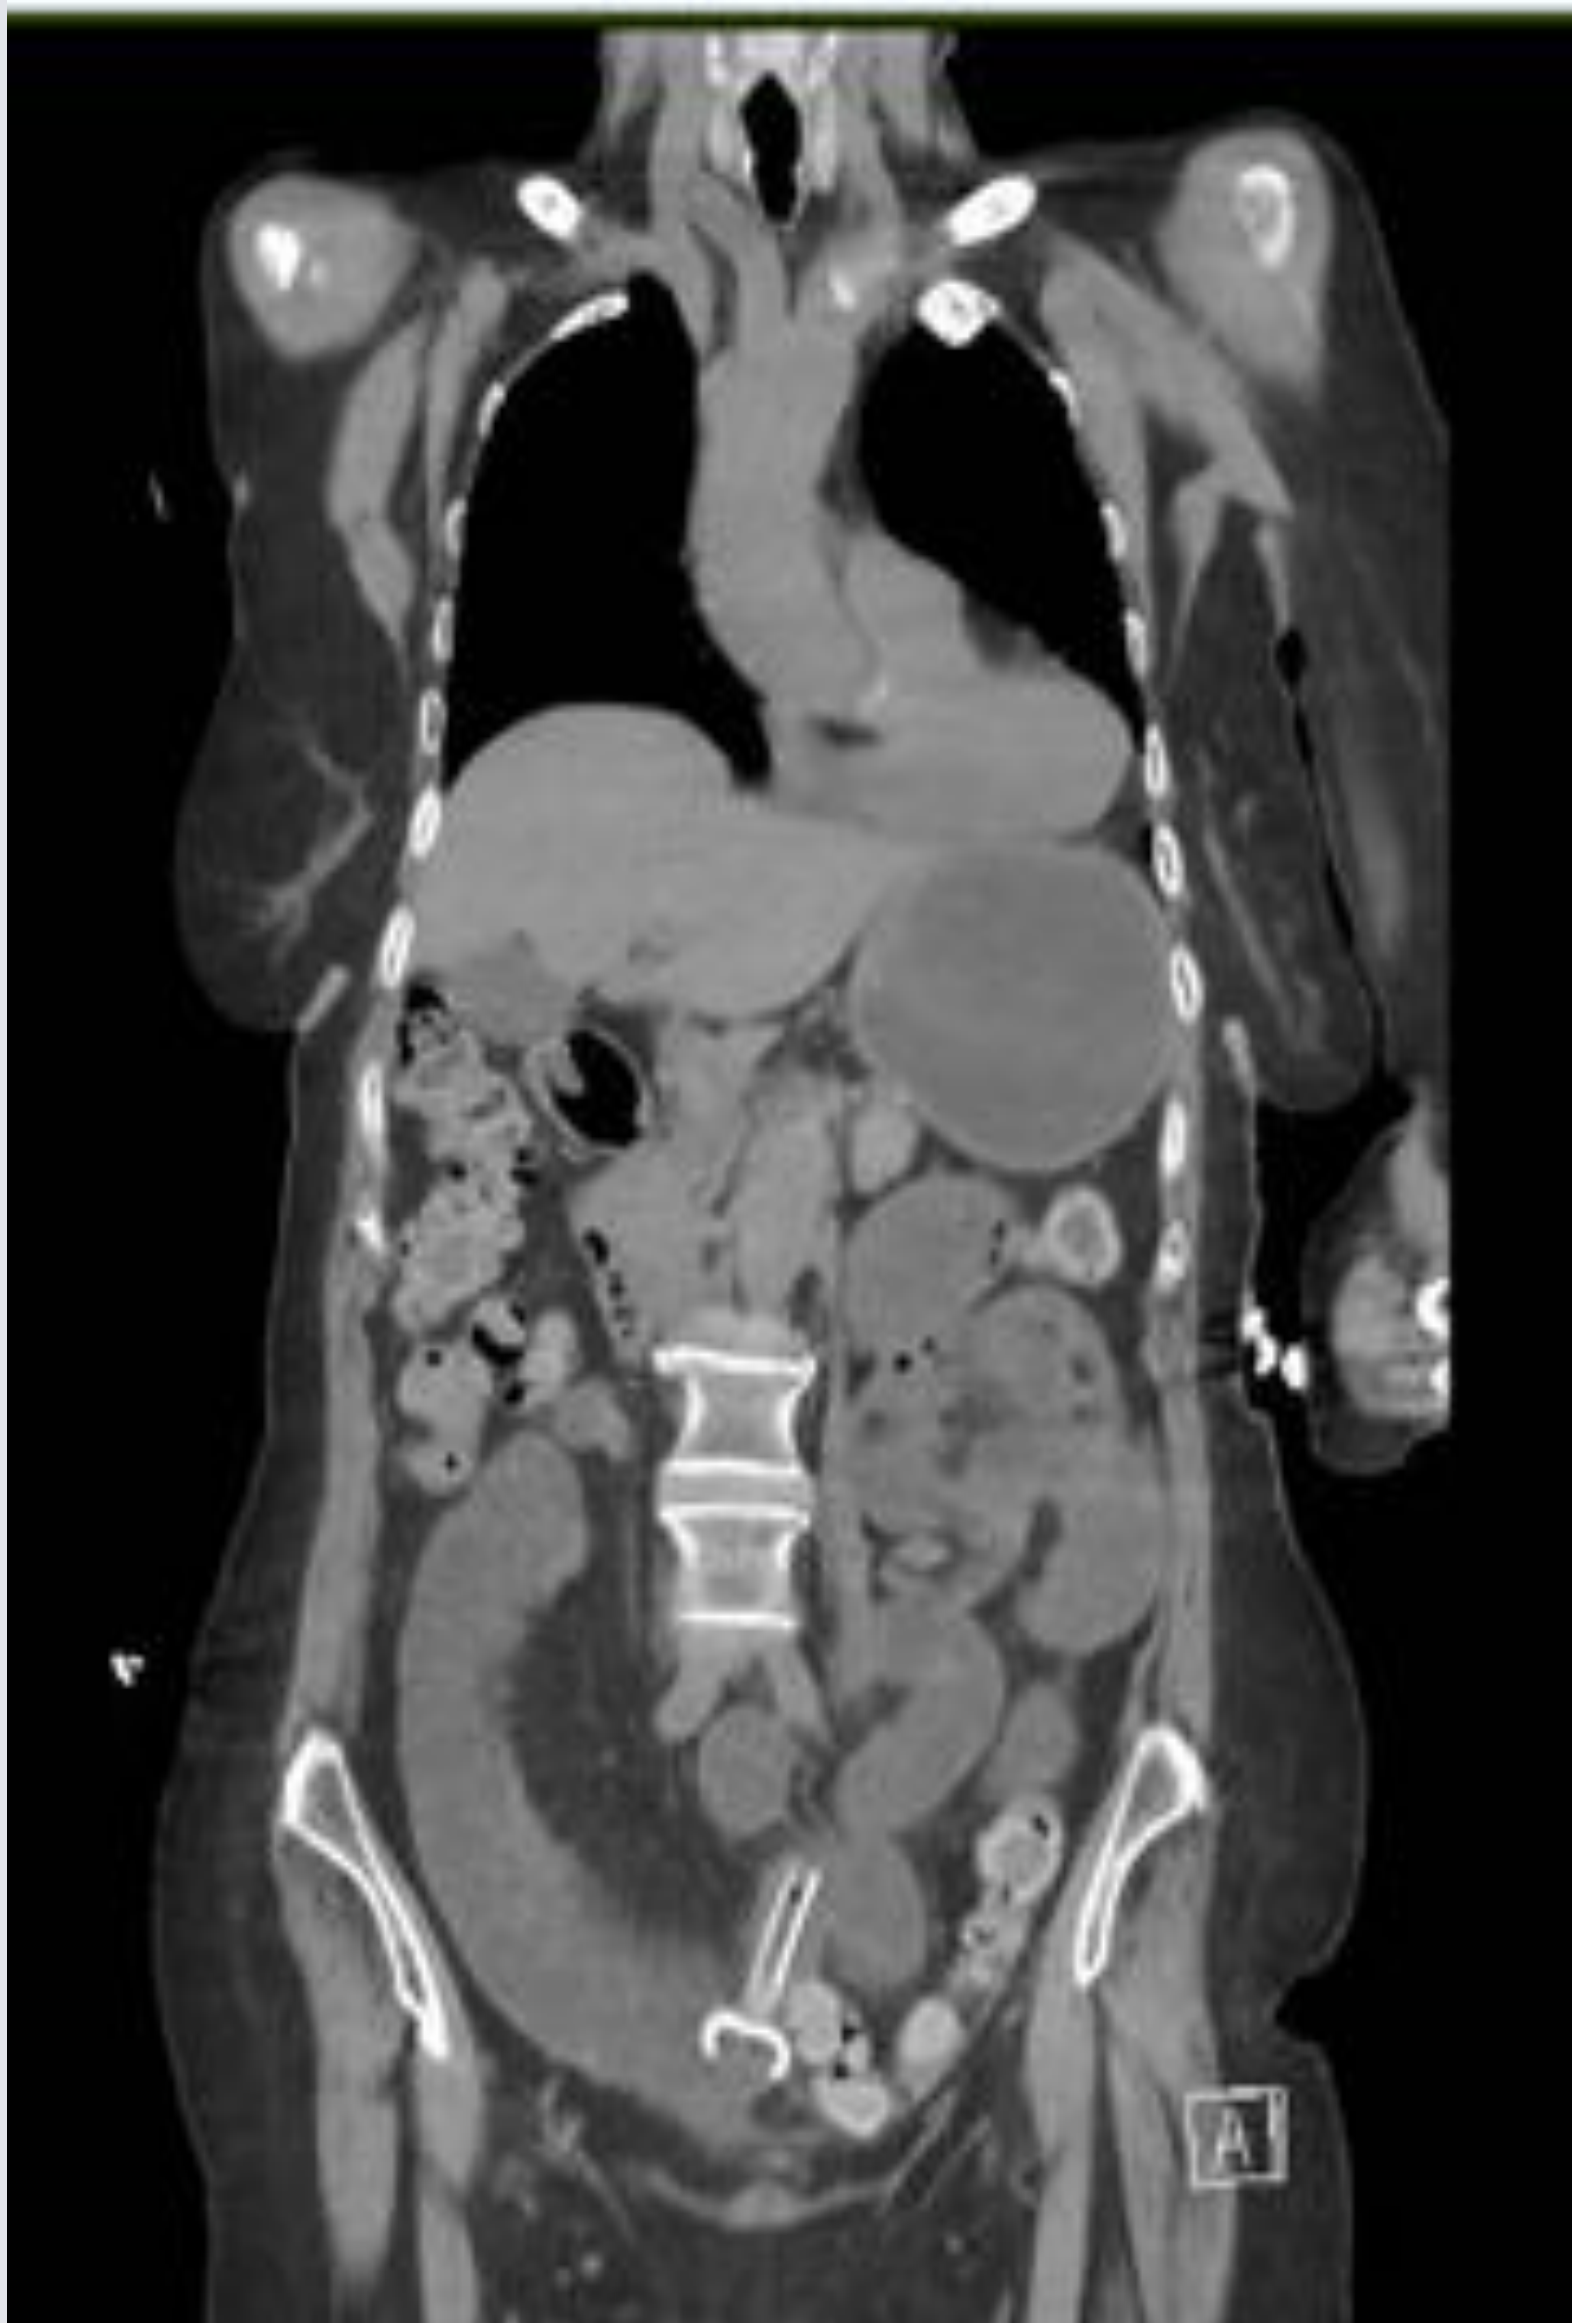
CT scan showing retained PEG Tube and dilated proximal small bowel
